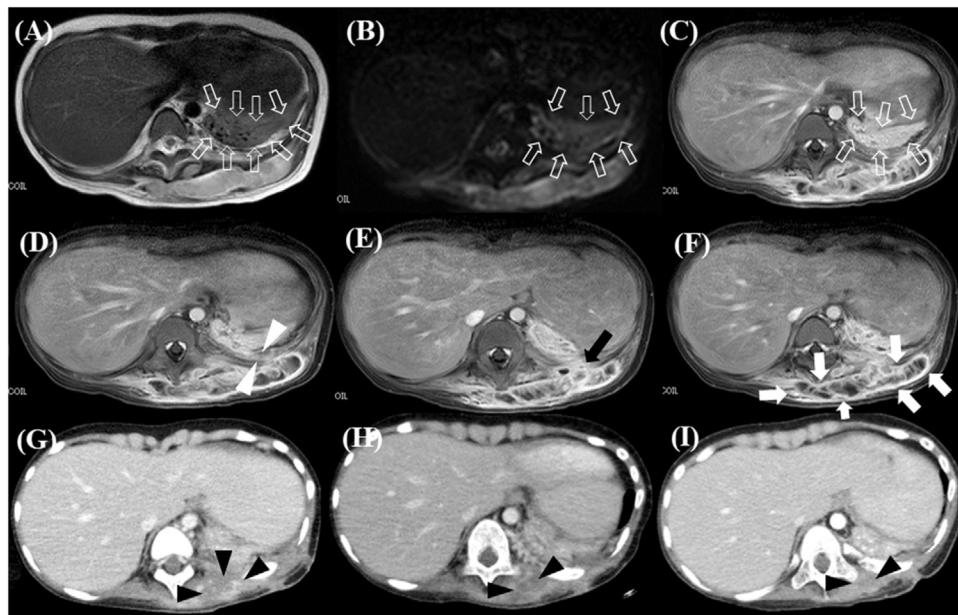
Magnetic resonance imaging (MRI) seven days after admission ((A)–(F)) and computed tomography (CT) 13 days (G) and 24 days (H) after admission and a month after discharge (I). T2-weighted image (T2WI) (A) and diffusion-weighted image (DWI) (B) of MRI revealed high intensity area, indicating empyema in the left lower lobe of the lung (open white arrow). Enhanced MRI (craniocaudal direction) (C)–(F) showed that the caudal part of empyema of the left lung had penetrated the pleural wall (white arrow head; (D)) and spread to the subcutaneous area (black arrow; (E)) of extrathoracic tissue of the left back (white arrow; (F)), consistent with empyema necessitatis. CT after 13 days (G) showed decreased subcutaneous abscess. However, enhanced lesions were still present (black arrow head). CT after 24 days (H) and a month after discharge (I) showed no enhanced area and new subcutaneous abscess (black arrow head).
